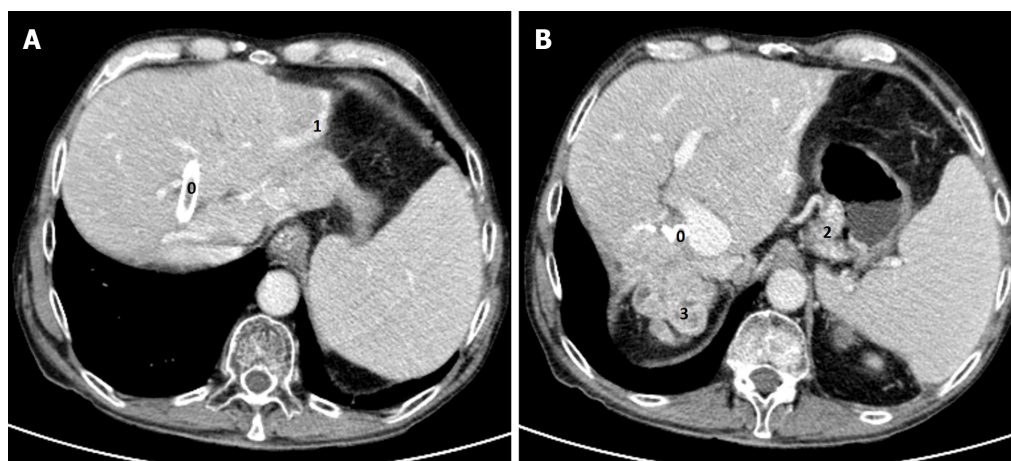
Contrast-enhanced computed tomography (portal phase). A: Biliary prosthesis (0), and abnormal vascular hepatic vein in the most marginal aspect of the left liver lobe related to a portosystemic shunt (1); B: Enlarged vein in the gastrohepatic ligament associated with small gastric mural varicose veins (2). Metastatic lesions at the hepatic hilum (3).
